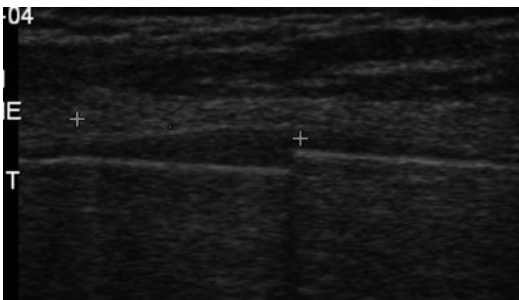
Ultrasound examination during lengthening: accurate readings can be obtained by using noninvasive ultrasound method (Courtesy of Behrooz A. Akbarnia, MD)
